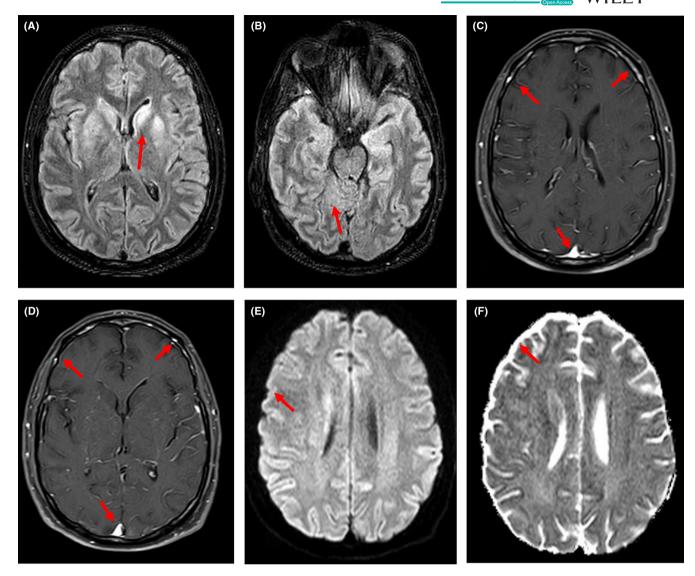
Axial FLAIR MRI showing high signal intensities in the bilateral caudate and lentiform nuclei (A) and left medial temporal lobe (B). Postcontrast brain MRI shows diffuse meningeal enhancement (C and D). Axial diffusion-weighted imaging (DWI) (E) and apparent diffusion coefficient (ADC) (F) show restriction diffusion in cortical regions.
